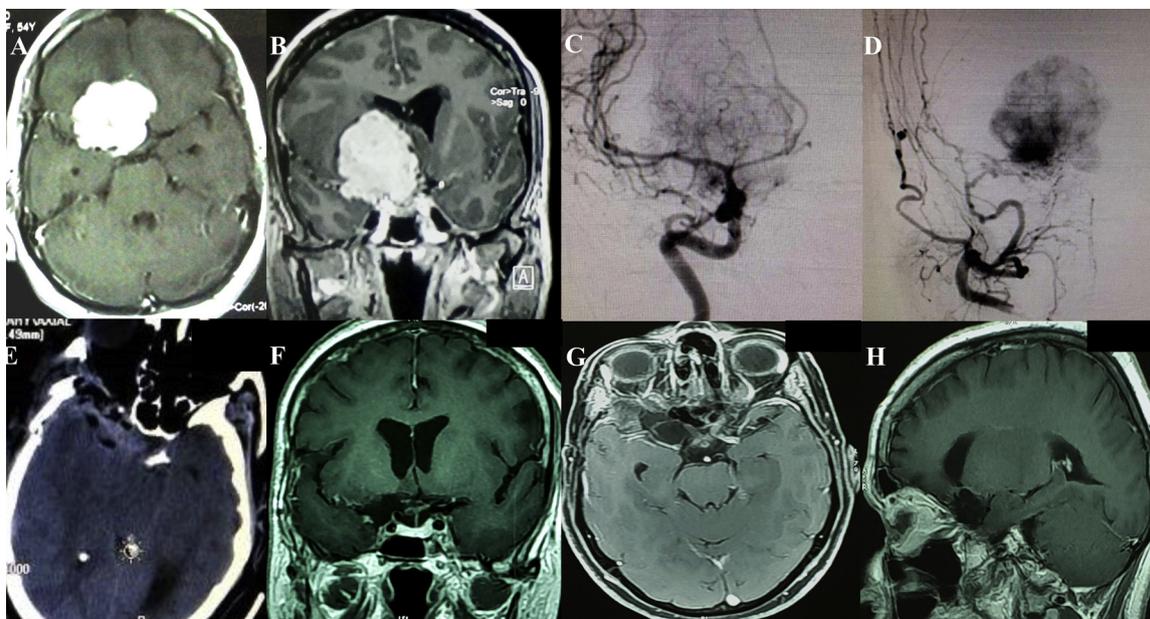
A & B) Preoperative contrast MRI showing clinoidal meningioma with encased vessels C) & D) DSA Showing thinning of A1 with mild blush from ICA and with intense blush from ECA E) Immediate postoperative NCCCT showing GTR. D–F) 3 month follow up MRI showing no residual lesion.
